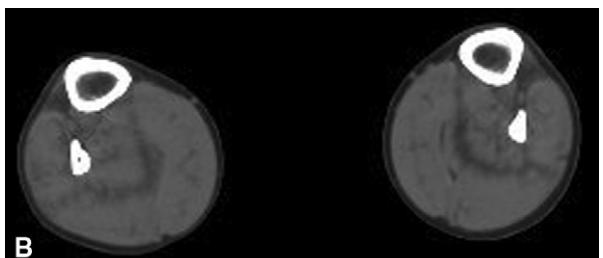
Distal myosinopathy (Laing myopathy). (A) The generalized reduced muscle bulk and contractures of the ankles, combined with scoliosis (operated) and neck flexor weakness, make an unusual posture. (B) Magnetic resonance imaging of muscle showing rather selective degenerative involvement of anterior tibial muscles compared with other lower leg muscles.
